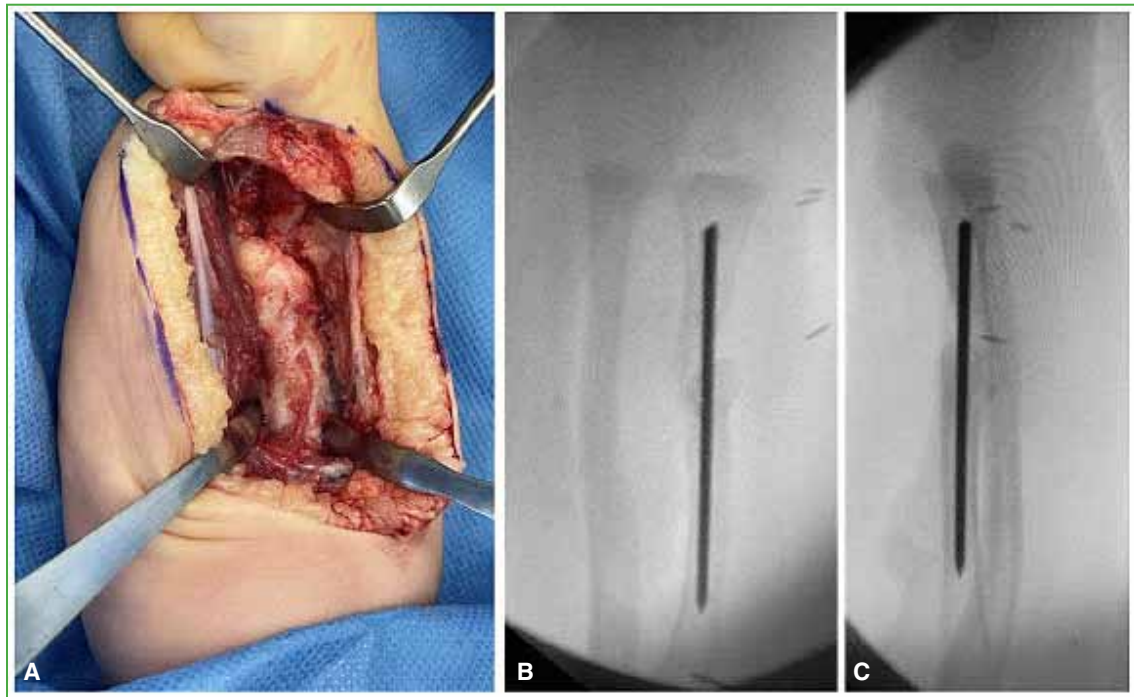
A. Abnormal radial periosteum (fibrous hamartoma). B and C. Anteroposterior and lateral radiographic images, respectively, of K-wire placement.
